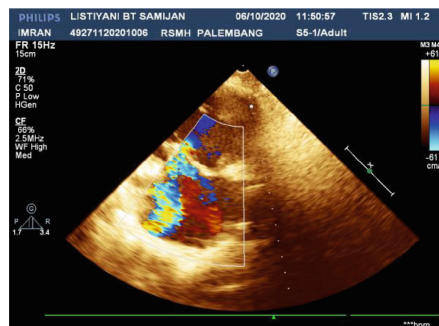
Echocardiography showed pulmonic regurgitation.
